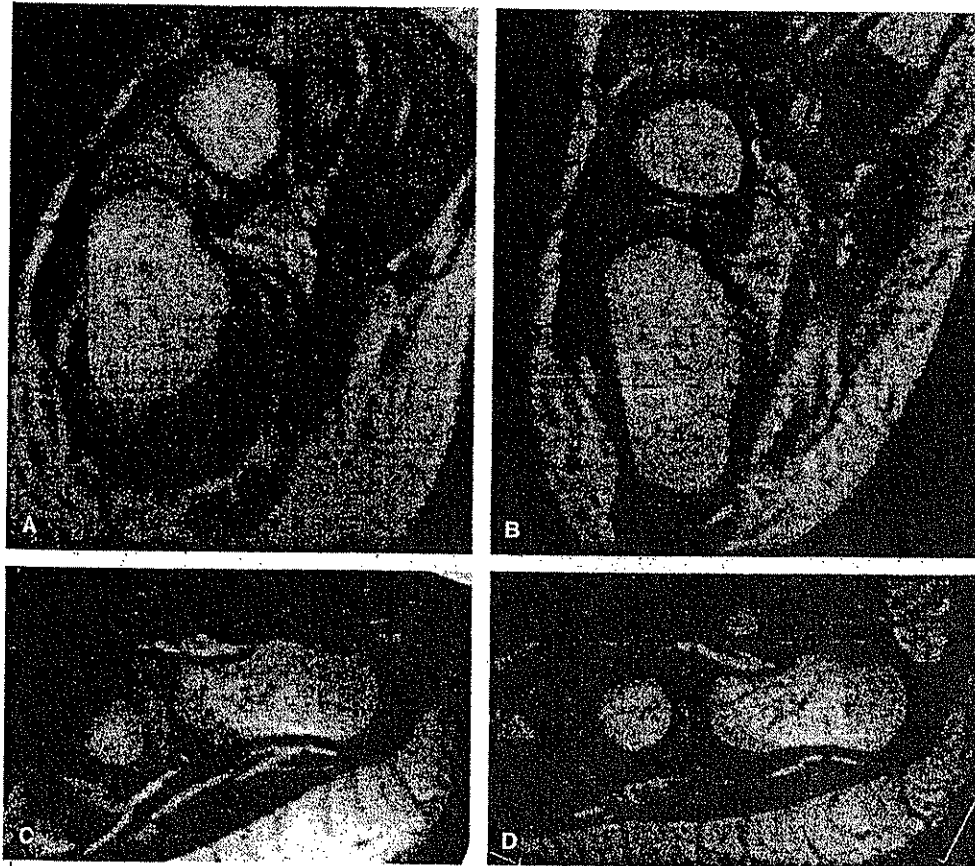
Patient 3. Oblique axial magnetic resonance images perpendicular to the calcaneocuboid joint show that the wedge-shaped distal calcaneus and the medial calcaneocuboid displacement improved but did not correct completely from the first scan at 11 months of age (A) to the third scan at 14 months of age (B). The sagittal images perpendicular to the bimalleolar axis show the plantarflexion deformity of the calcaneocuboid joint (C) and its response to manipulation and casting by the Ponseti method. The deformity corrected with remodeling and realignment of the distal calcaneal articular surface to a more normal orientation, where it is perpendicular to the long axis of the calcaneus. The cuboid remodeled so that its proximal and distal articular surfaces became more parallel. However, a new iatrogenic deformity became apparent, with an upturning of the distal end of the calcaneus, making the profile of the calcaneus similar to that of a Dutch wooden clog (D).
